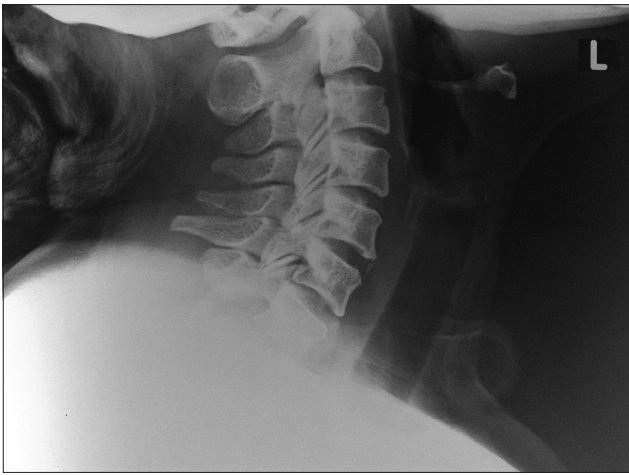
The initial lateral X-ray performed in August and reported as “normal” with cervical degenerative changes. The X-ray is incomplete since it did not show the C7/T1 junction but it actually shows a fracture of the C7 spinous process. The anterior-posterior view of her neck was not contributory
